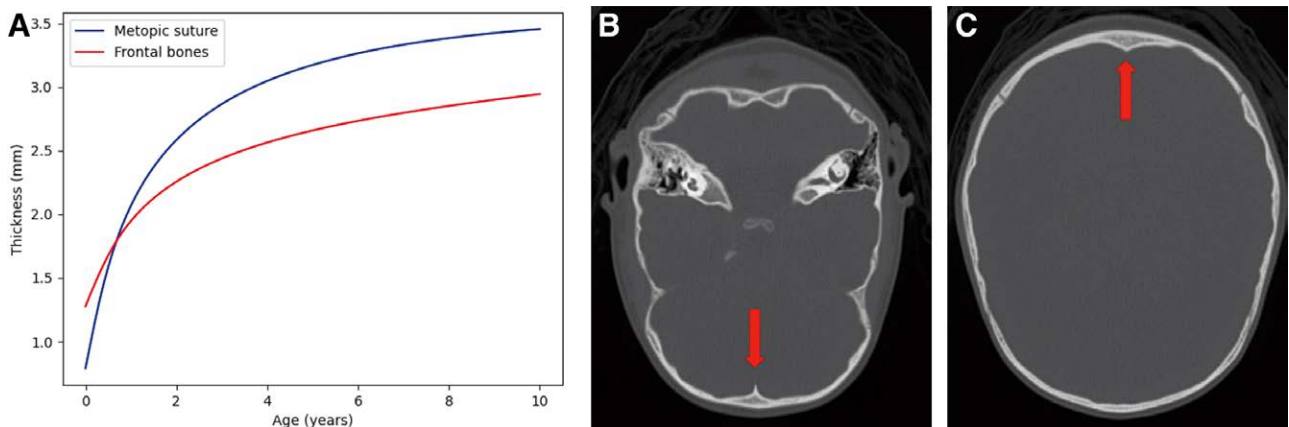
A, Average cranial bone thickness in the metopic suture and in the surrounding frontal bones. B, CT slice of a 4.58-year-old subject showing a substantial thickening at the metopic suture (indicated with a red arrow) compared with the frontal bones. C, CT slice of the same subject showing a similar thickening pattern in the sagittal suture indicated with a red arrow.
